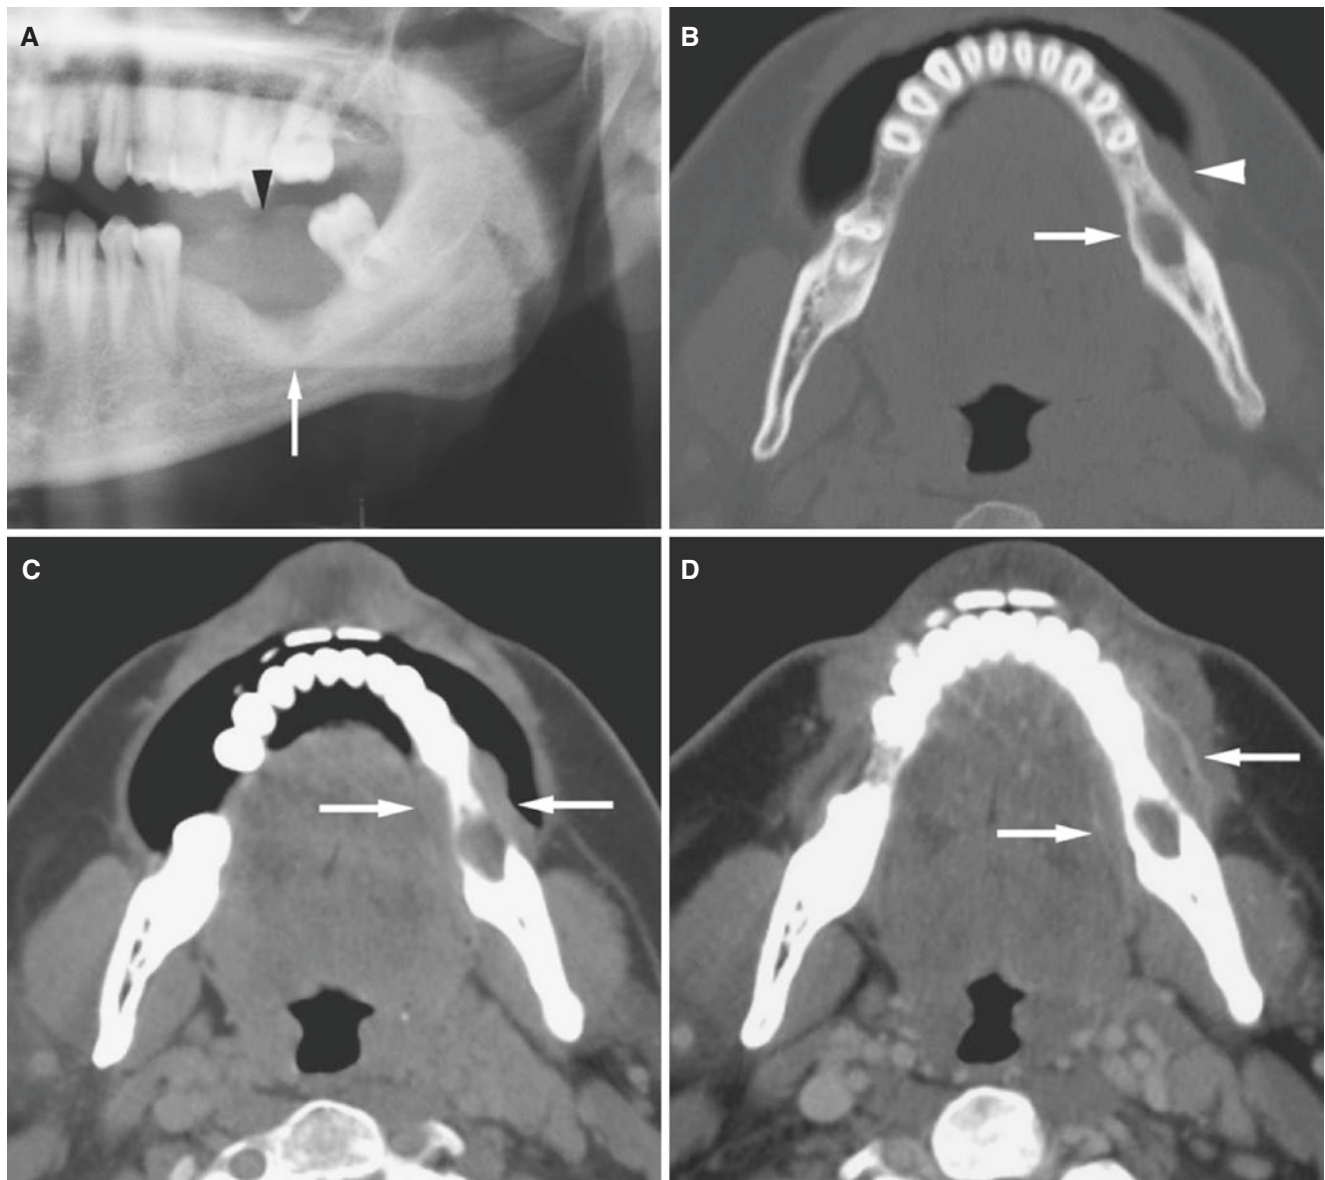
Squamous cell carcinoma, mandible; 37-year-old male with painless gingival soft-tissue swelling. (A) Panoramic view shows diffuse bone destruction (*arrow*) and soft-tissue mass (*arrowhead*). (B) Axial CT image with cheek blowing shows bone destruction (*arrow*) and soft-tissue mass (*arrowhead*) adherent to the mandible. (C) Axial
